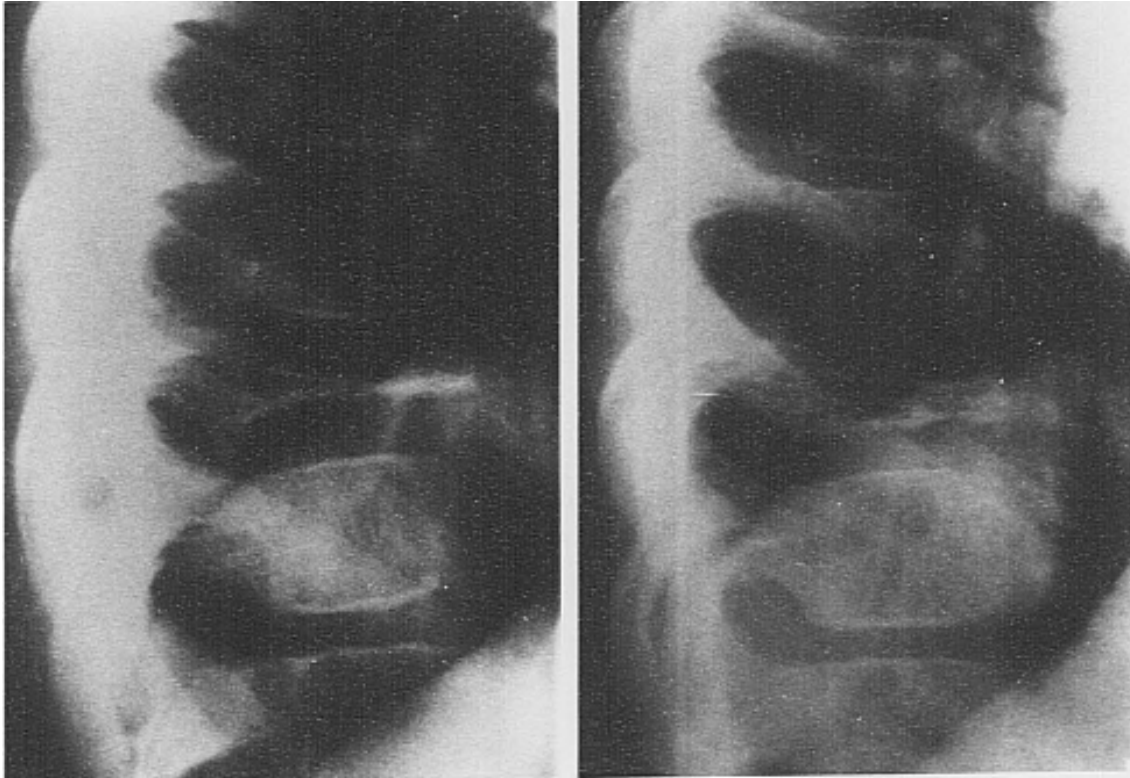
A: Lateral radiograph at diagnosis of a 6-year-old boy with a T10 vertebral plana. B: Eight years later, the disc spaces were of normal thickness, and the collapsed vertebra had recovered 40% of its height.
